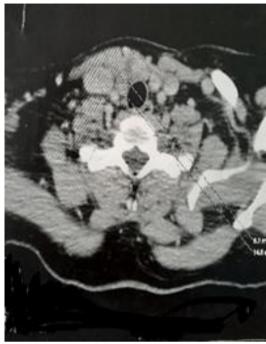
neck computed tomographic (CT) showing a parathyroid adenoma
